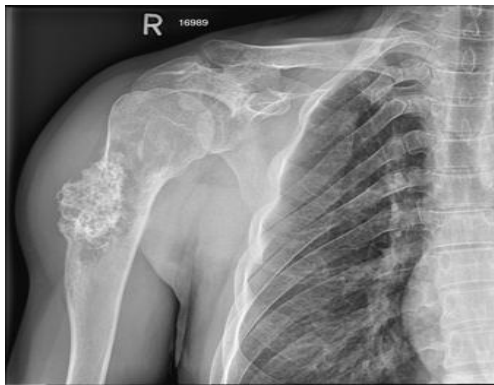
X-ray showing expansile tubulation deformity of proximal humerus .
